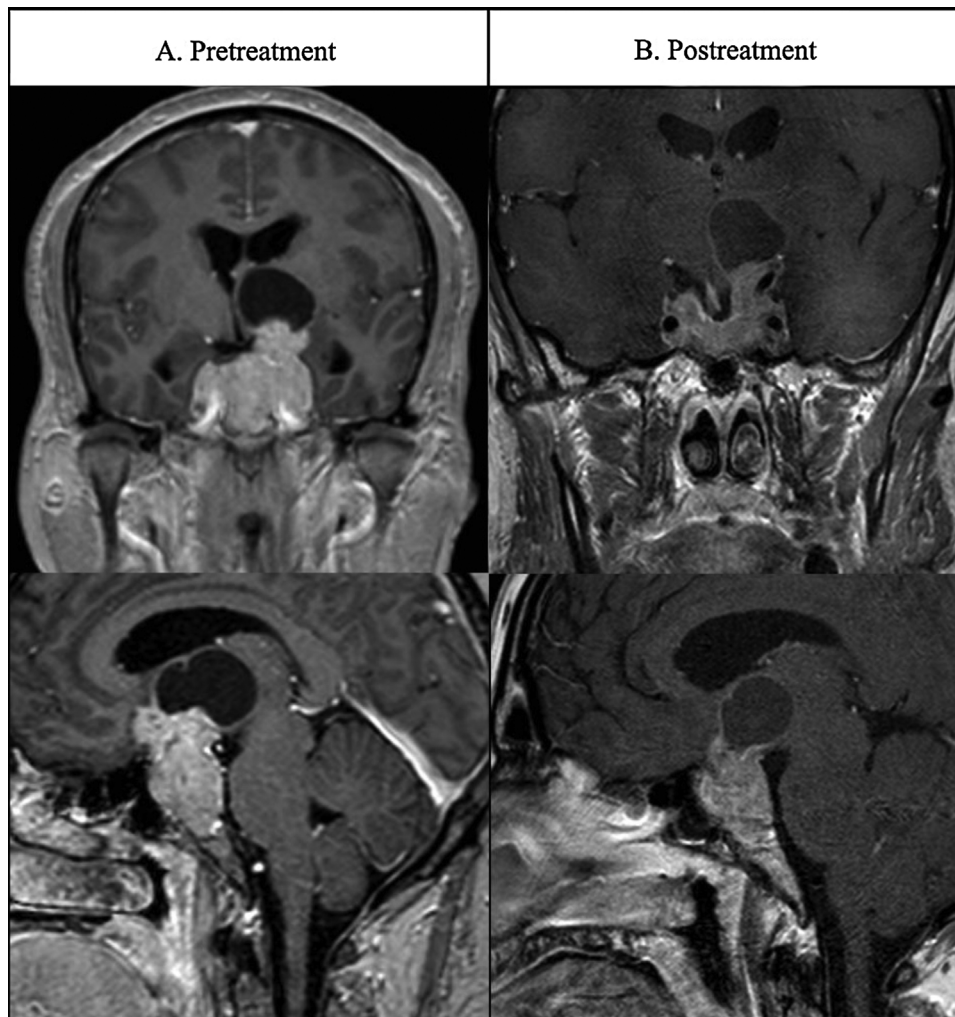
Patient 3's MRI images at presentation and after medical treatment.
